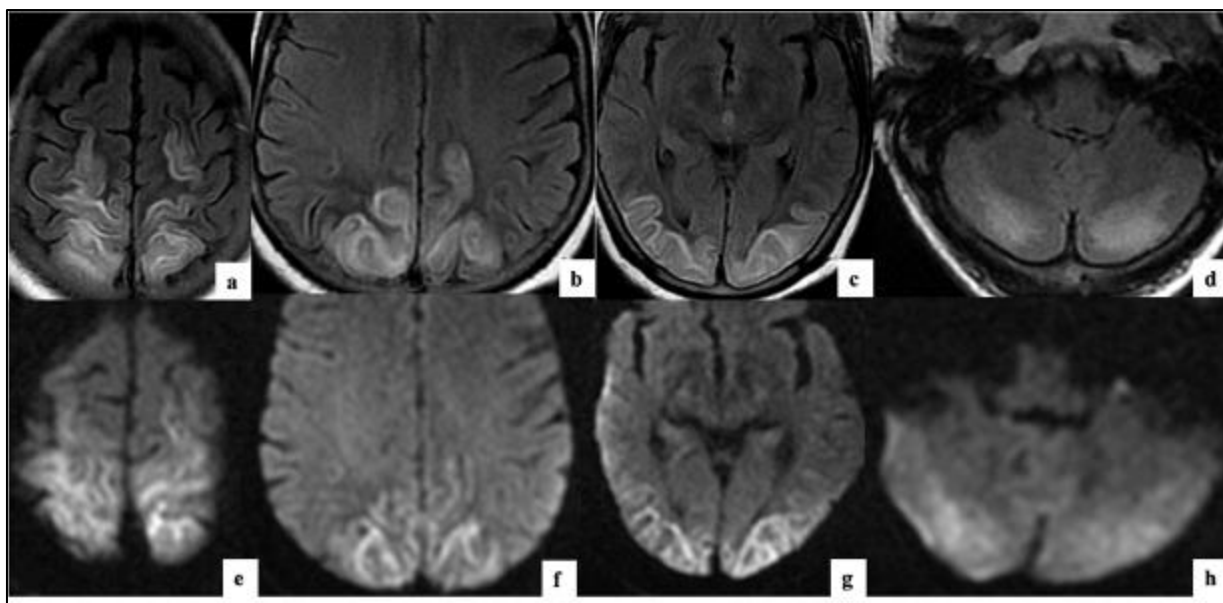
(a – h). Axial MRI, FLAIR and DWI images : Hyperintense FLAIR (a – d) signal in the posterior frontal and occipitoparietal regions, as well as in the posterior cerebellum, with a hyperintense signal on DWI (e – h), consistent with cortical infarction
